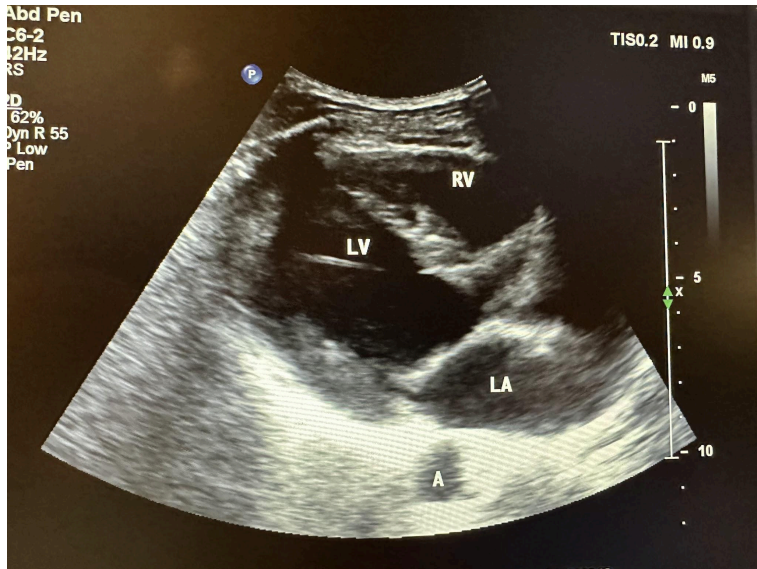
Parasternal sagittal view of the heart showing the left ventricle, right ventricle, left atrium, and aorta.
